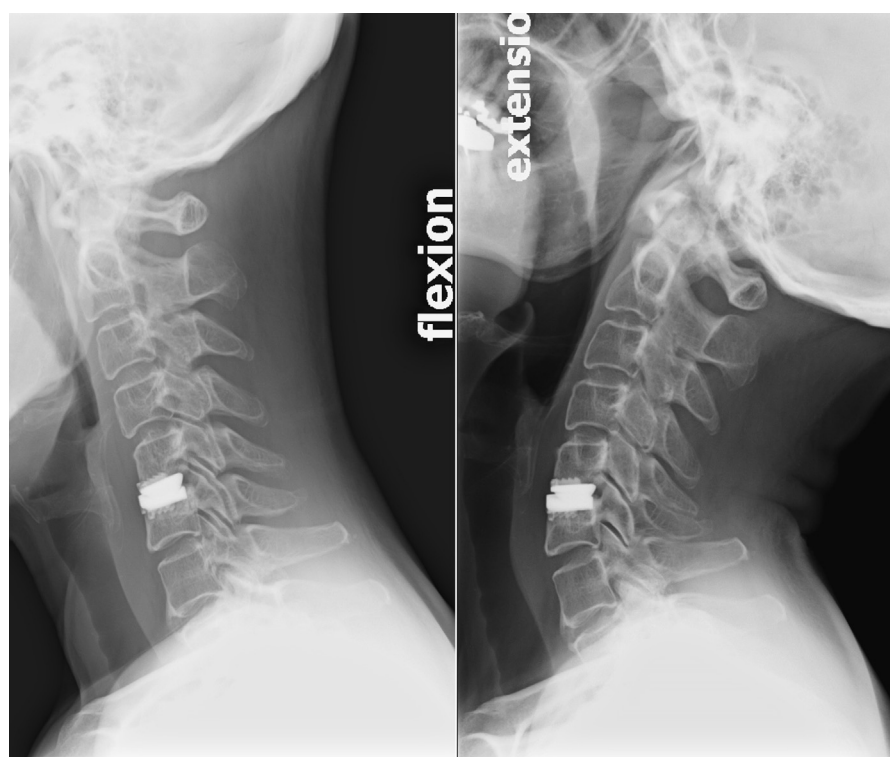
Postoperative dynamic radiographs. The patient underwent cervical total disc replacement for a herniated disc causing cervical radiculopathy. Postoperative lateral radiographs demonstrated the preserved segmental motion at C5/C6.
